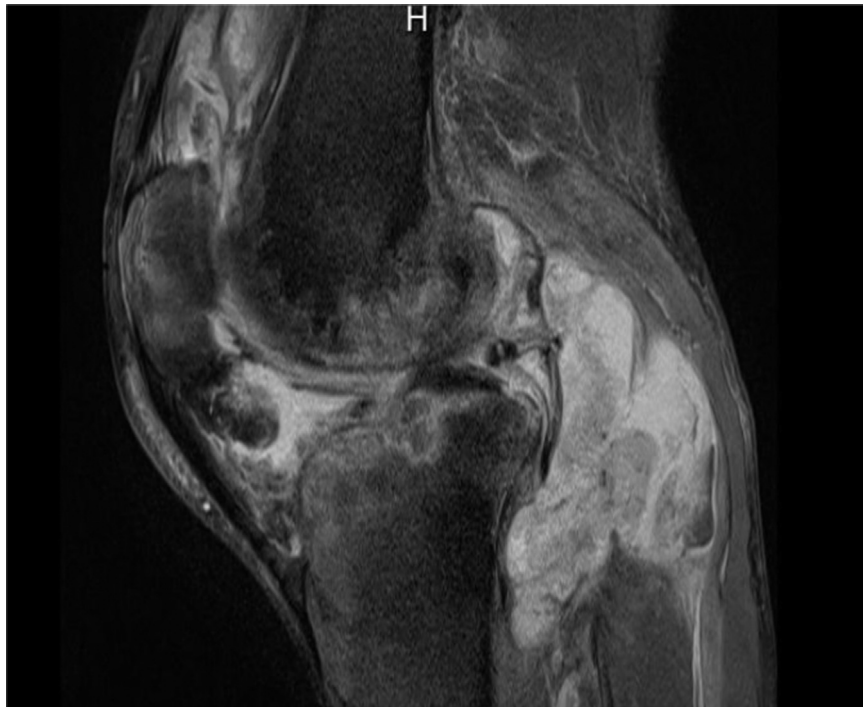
MRI demonstrating large complex joint effusions and bone marrow edema within the femoral condyles and tibial plateaus.
